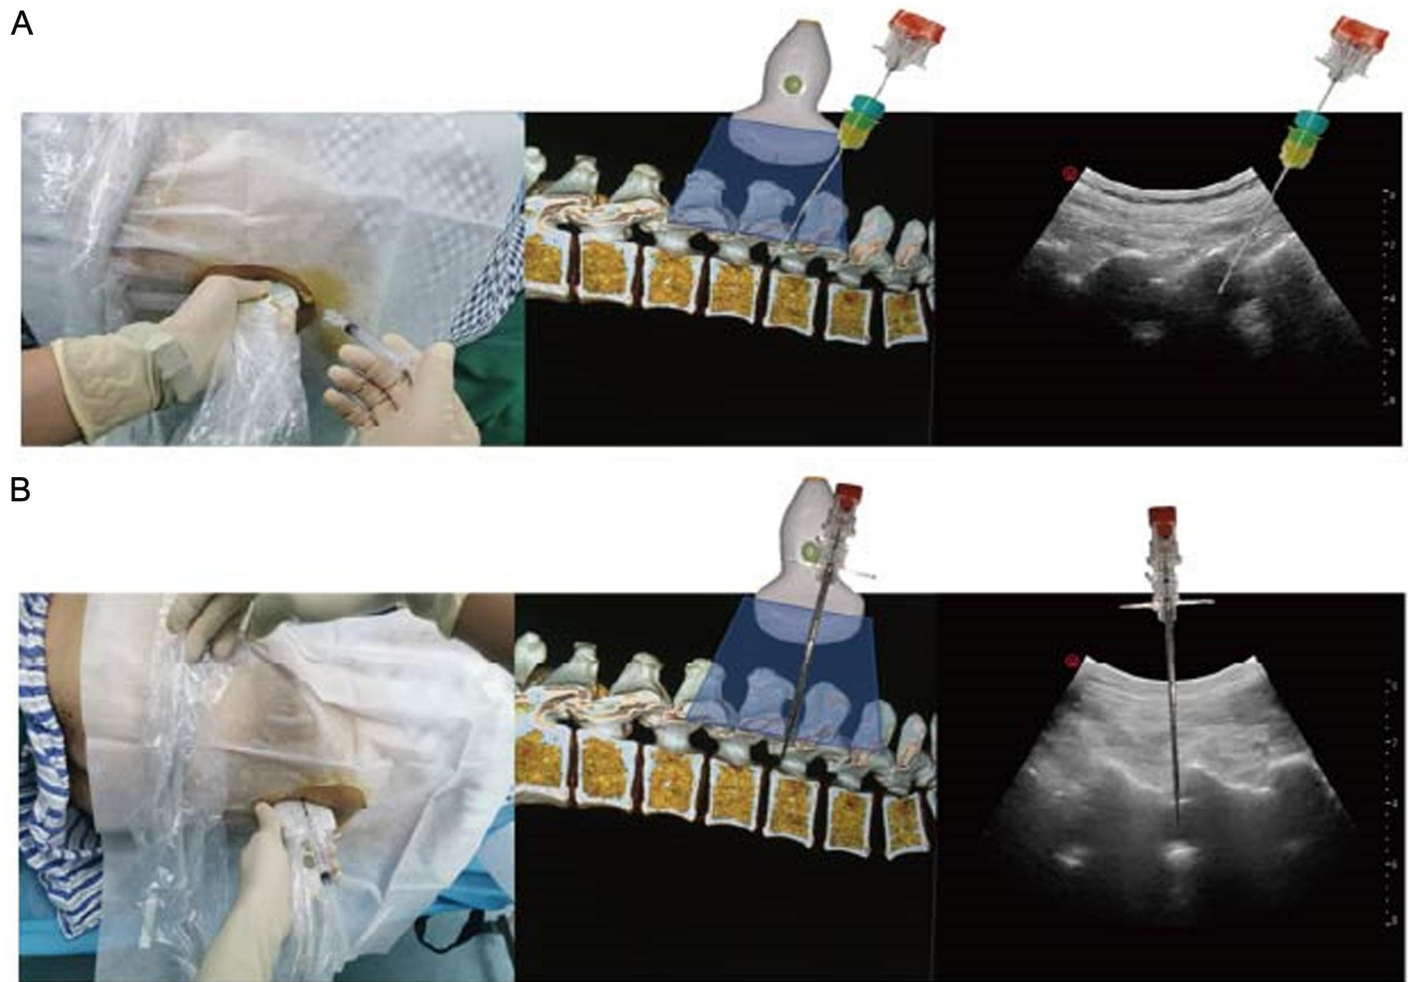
Comparison of long-axis in-plane and out-of-plane ultrasound-guided techniques. Compared with short-axis scanning, the long-axis view provides clearer visualization of intraspinal structures and allows continuous display of multiple interlaminar spaces, facilitating identification of the widest or most distinct acoustic window. The long-axis in-plane technique (A) enables direct visualization of the needle trajectory but is limited by patient positioning and operator handedness. In contrast, the long-axis out-of-plane technique (B) is not constrained by these factors, allows tracking of needle tip advancement, and is particularly suitable for patients with restricted positioning or narrow intervertebral spaces.
